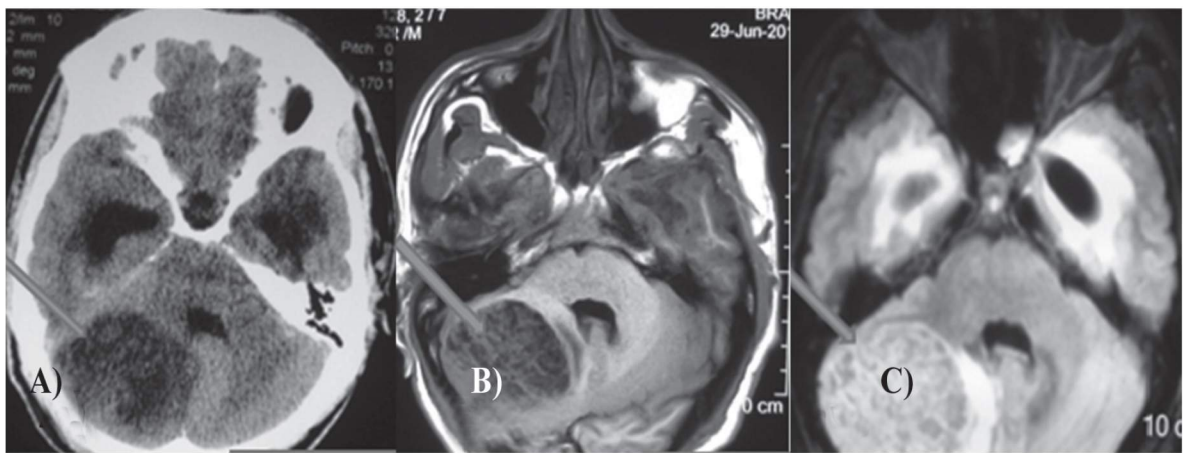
A) Non-Contrast Computed tomography (CT) showing right cerebellar mass (Arrow head), B) T1-weighted MRI and C) MRI FLAIR sequence
